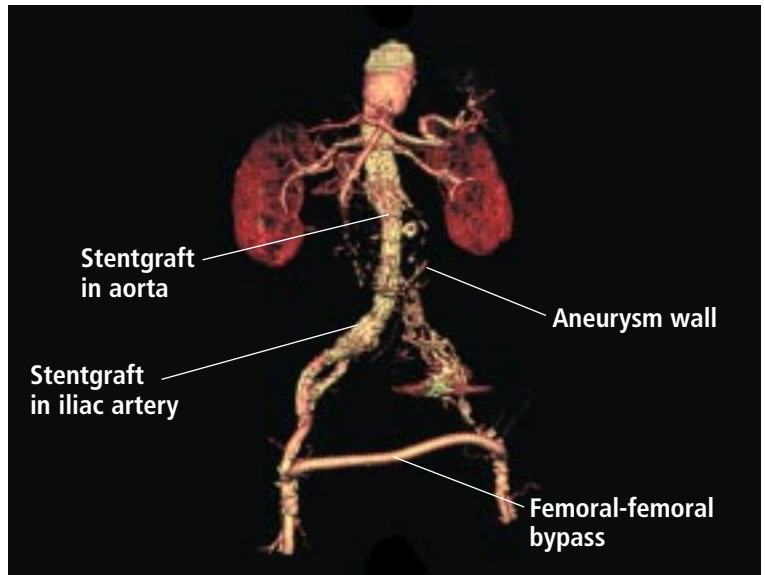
This computed tomographic scan reconstruction depicts a follow-up study on a patient who underwent successful endovascular repair of a ruptured abdominal aortic aneurysm with a stentgraft and femoral-femoral bypass.
